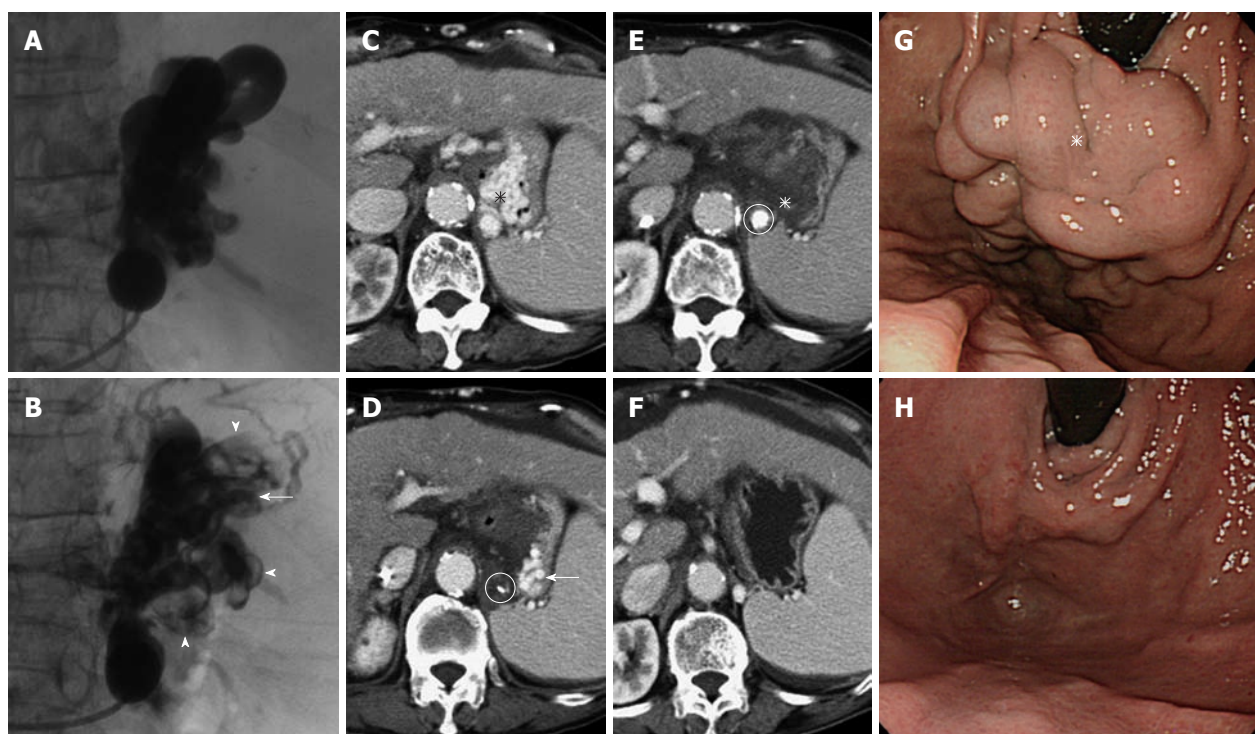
Additional injection of the sclerosant. A: Fluoroscopic image obtained during the first balloon-occluded retrograde transvenous obliteration (BRTO) shows full opacification of the gastric varices and gastroduodenal shunt; B: Fluoroscopic image obtained during the second BRTO (next day) shows partial opacification of the varices and shunt, suggesting residual varices (arrow) and thrombosis of the varices and shunt (arrowheads); C: Contrast-enhanced computed tomography (CE-CT) before BRTO shows large varices (asterisk); D: CE-CT after the first BRTO shows residual varices (arrow) in the lateral portion of the stomach. The microcatheter tip (circle) is in the gastroduodenal shunt close to the varices; E: CE-CT after the second BRTO shows complete thrombosis of the varices (asterisk). The sclerosant with contrast medium (circle) is detected in the gastroduodenal shunt; F: CE-CT 3 mo after BRTO shows complete disappearance of the varices; G: Endoscopy before BRTO shows bulky varices (asterisk); H: Endoscopy 3 mo after BRTO shows complete disappearance of the varices.
